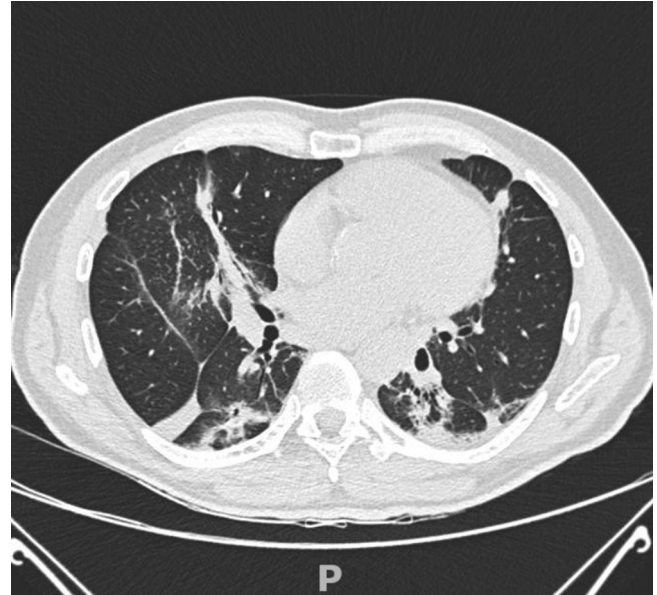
Chest high-resolution computed tomography scan: interstitial lung disease
